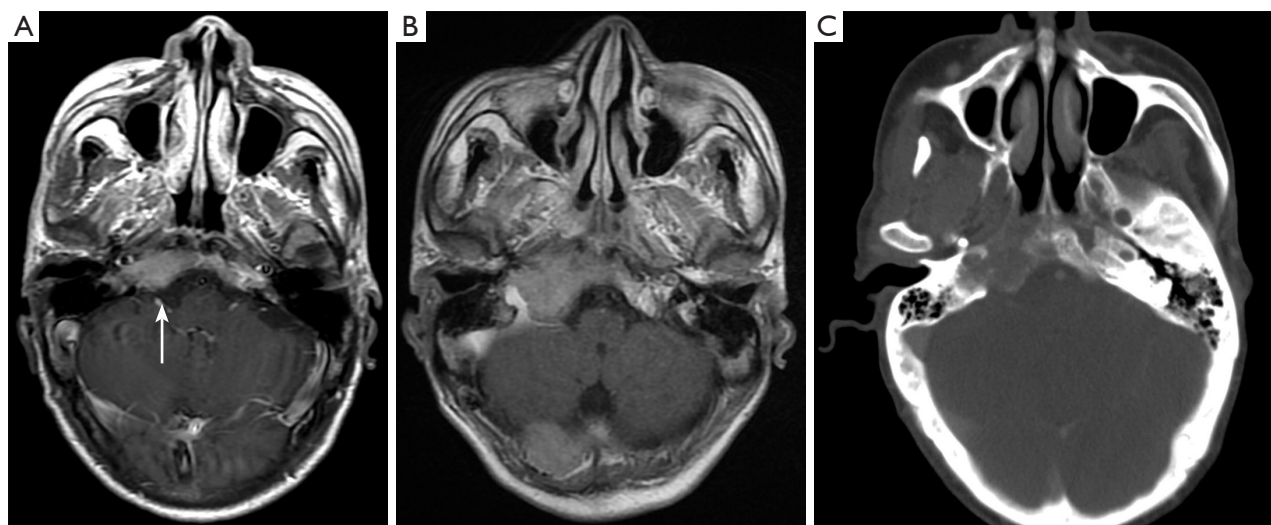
Blind spot in brain imaging: skull base. Scans of a 53-year-old male with hepatocellular carcinoma and orbital metastasis undergoing comprehensive treatment. To assess the efficacy of treatment for orbital metastasis, the patient underwent a brain MRI examination. (A) The MRI showed an abnormal signal lesion on the right clivus (arrow), which demonstrated a progressive enlargement during the follow-up process (B); an abnormal signal of the occipital bone was also observable in the right posterior cranial fossa (B). (C) CT bone window revealed right clivus osseous destruction. MRI, magnetic resonance imaging; CT, computed tomography.
